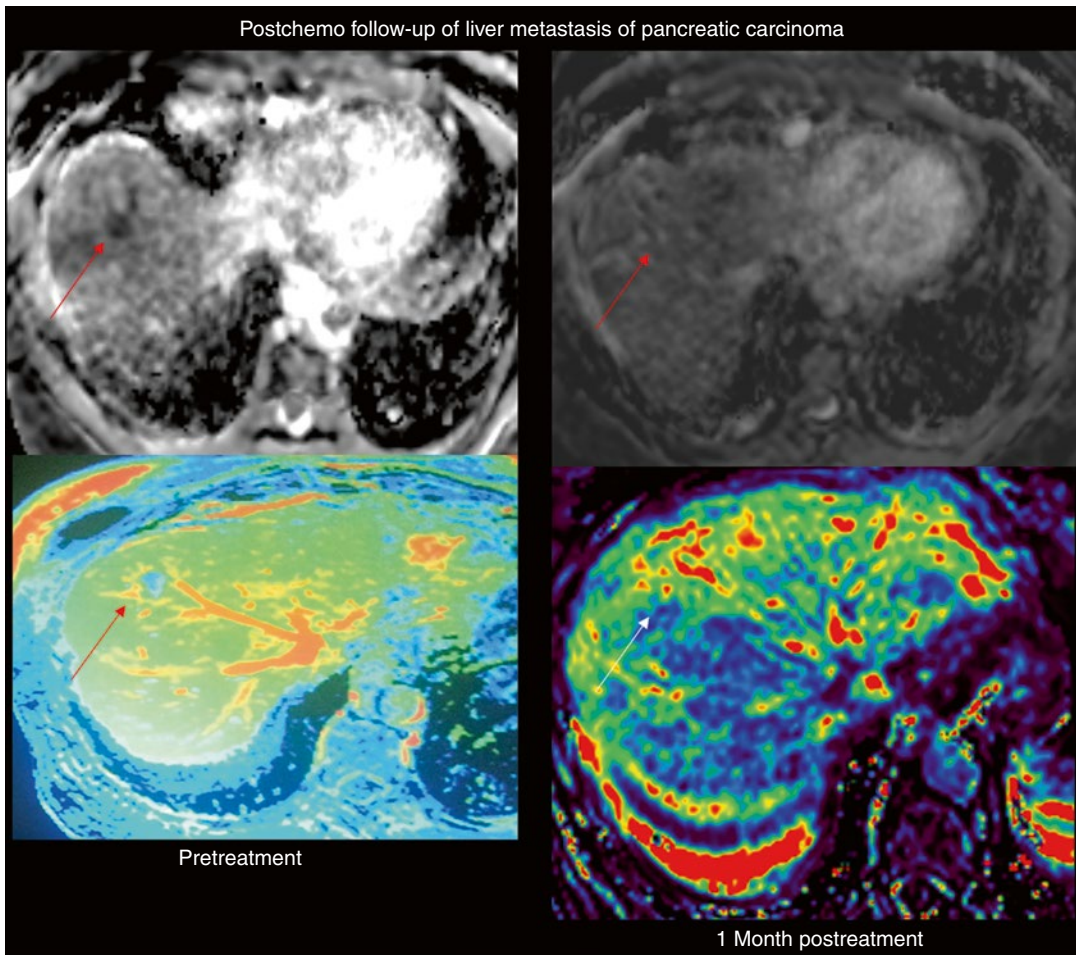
Follow-up functional MRI pre- and post-chemotherapy in a patient with a metastasis (arrows) from pancreatic carcinoma. On pretreatment MRI (left column images), there is a lesion in segment 8 with very low ADC
